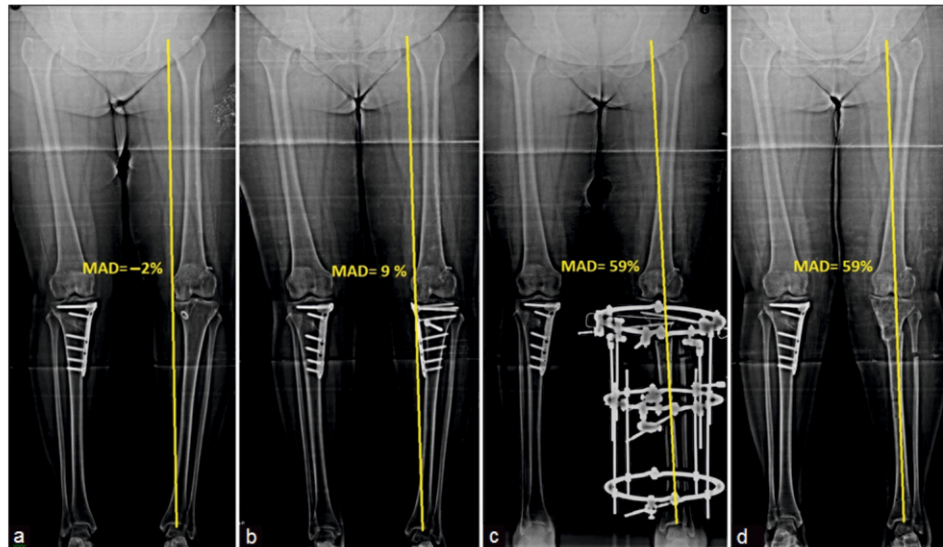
(a) Preoperative full-length X-ray of a 48-year-old female with left MCOA, MAD is at -2%; (b) postoperative FDCO full-length X-ray, MAD is undercorrected to only 9%. This was our first case of FDCO; (c) repeat osteotomy was performed after 5 months, as a distally convex focal dome, fixed with an Ilizarov fixator. MAD improved to 59%. Proximal fibular osteotomy needed to achieve angulation–translation of the focal dome; (d) four months after surgery Ilizarov fixator removed. Correction maintained at 59% of joint width. FDCO: Focal dome condylar osteotomy, MAD: mechanical axis deviation, MCOA: Medial compartment osteoarthritis
